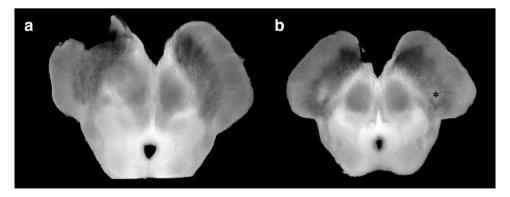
Ex vivo T₂-weighted MRI images of the mid-mesencephalon in a PD patient (a) and healthy control (b). Nigrosome-1, marked as * on the right side of (b) is seen in the healthy control but is absent in the PD. Nigrosome-1 on the left side of (b) was not marked to
